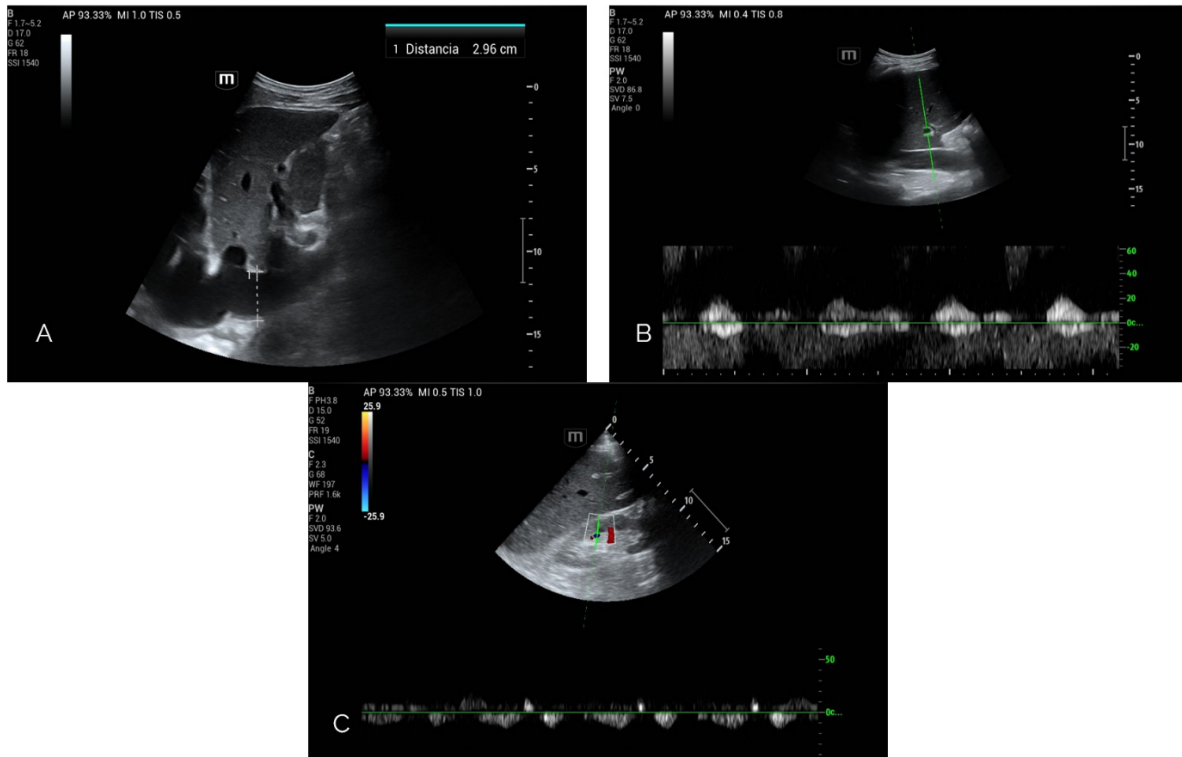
Point of care ultrasound findings
